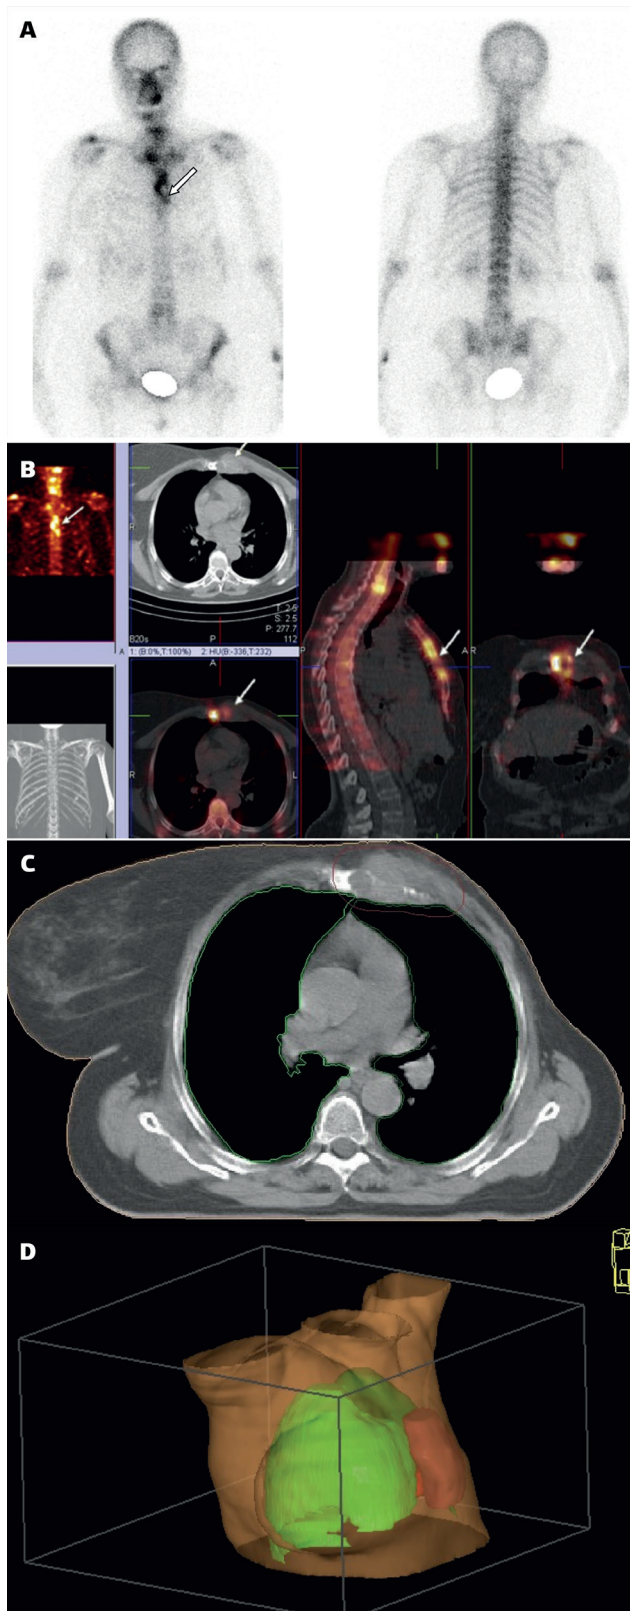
A: A patient with breast cancer localized in the inner quadrant on the left. Whole body bone scan showed a solitary metastatic bone lesion in the sternum (arrow). B: SPECT-CT revealed soft tissue formation in the ipsilateral parasternal space directly infiltrating the sternum (arrow). PTV (C) and radiation dose distribution (D).
